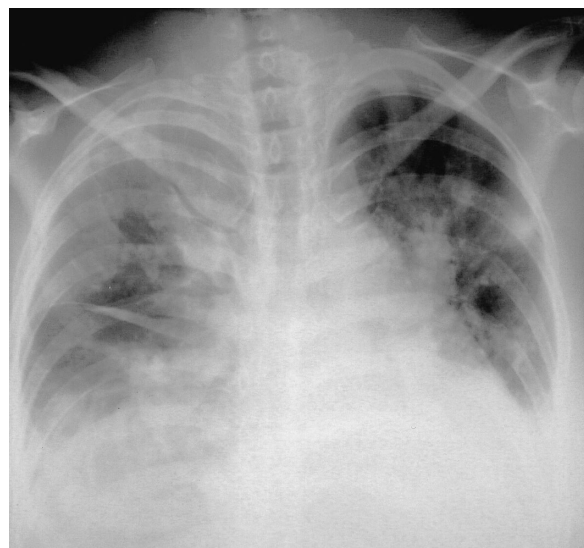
Chest radiograph on admission showing cardiomegaly, pulmonary congestion, and bilateral massive pleural effusion
